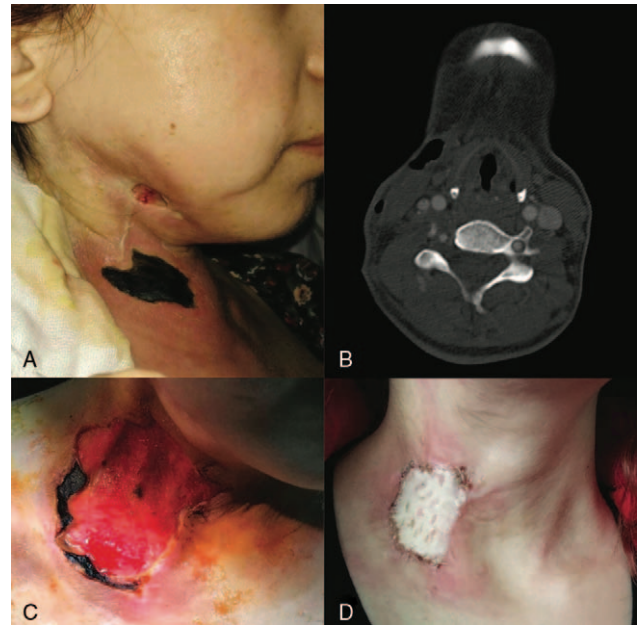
(A) The necrotic wound on the skin that is extending from the right submandibular region to the supraclavicular area, the fistula, and brown purulent discharge. (B) Axial computed tomography scan reveals gas images and fluid collection. (C) After surgical debridement. Infection is limited to superficial fascia and platysma. (D) Defect is reconstructed with a split thickness skin graft.
